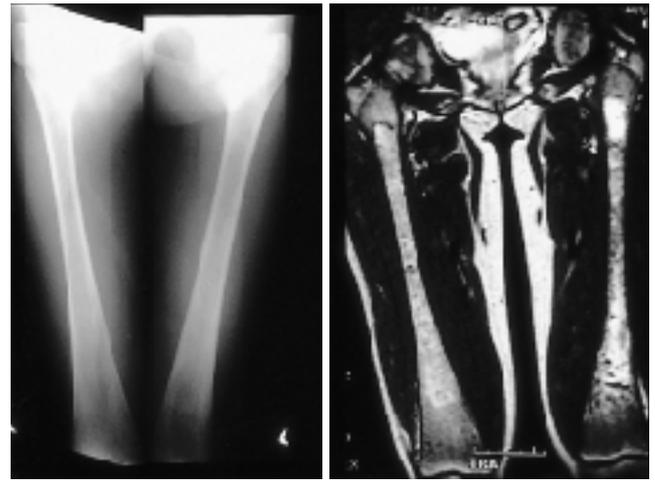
19 years old male, type I patient. (A) plain radiography and (B) fat saturated T2WI of femur. No remarkable bony resorption or sclerotic appearance can be found in plain film, while fat saturated T2WI clearly demonstrate infarction in both femur diaphysis.
